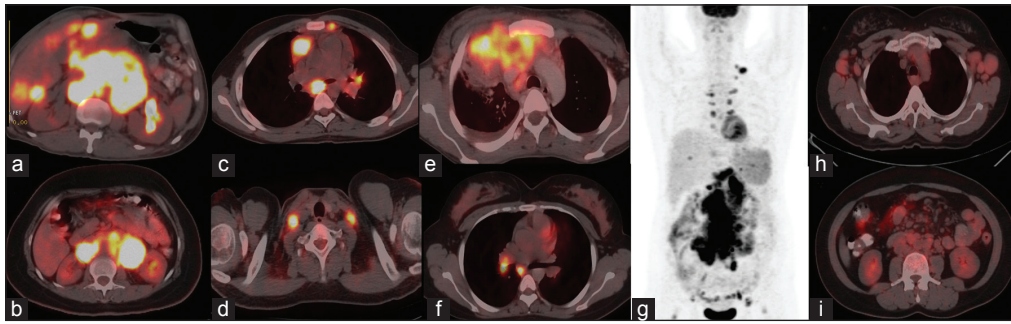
Transaxial F-18 fluoro-deoxy-glucose (FDG) positron emission tomography/computed tomography (PET/CT) images of two patients (a and b) with diffuse large B cell lymphoma (DLBCL) showing intense F-18 FDG uptake with maximum standardized uptake value (SUV_{max}) of 20.3 and 21.6 respectively. Transaxial F-18 FDG PET/CT images of a patient with Hodgkins lymphoma (c and d) showing intensely F-18 FDG avid lymph nodes in the mediastinum and neck ($SUV_{max} = 14.2$). The images discuss about F-18 FDG avidity of lymphomas. In general high grade lymphomas are known to be F-18 FDG avid with higher SUV_{max} and low grade lymphomas are known to be less F-18 FDG avid with lesser SUV_{max} values.^[1] According to International Harmonization Project recommendations HL, DLBCL, Follicular lymphoma, Mantle cell lymphoma are considered to be routinely F-18 FDG avid.^[2] anaplastic large cell lymphoma (ALCL) is also considered as 100% F-18 FDG avid according to recent literature^[3] and images (e and f) are consistent with this, showing intense F-18 FDG uptake in lymph nodal mass in the mediastinum and mediastinal lymph nodes in two patients with ALCL. Follicular lymphoma, which is a low grade lymphoma is also known to be routinely F-18 FDG avid^[4] and the maximum intensity projection image of a patient with Follicular lymphoma (g) shows intensely F-18 FDG avid lymph nodal mass in the abdomen ($SUV_{max} = 21.2$). on the contrary low grade lymphomas like small lymphocytic lymphoma (SLL) show very low F-18 FDG avidity as can be noted in transaxial images of the thorax and abdomen (h and i) of a patient with SLL involving b/l axillary and multiple retroperitoneal lymph nodes ($SUV_{max} = 3.4$). Due to variable FDG uptake in low-grade lymphomas, staging PET/CT is required to demonstrate the FDG uptake for response assessment at a later stage
